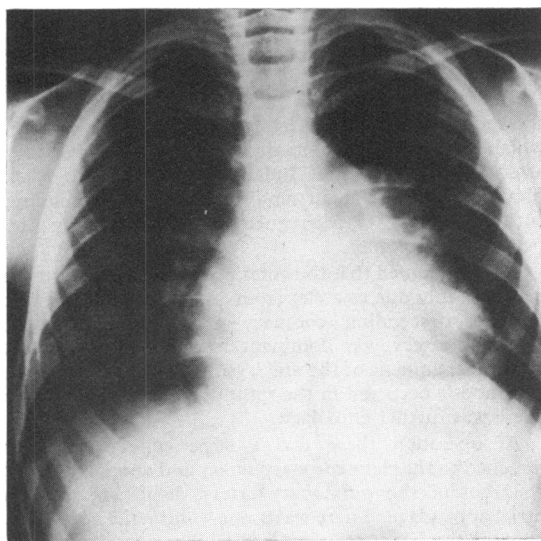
Penetrated chest radiograph of Case 1 at the age of 4 years. This shows cardiac enlargement and prominent bulge in the area of the left atrial appendage on the left heart border, which is caused by the aneurysm of the left anterior descending coronary artery.*
